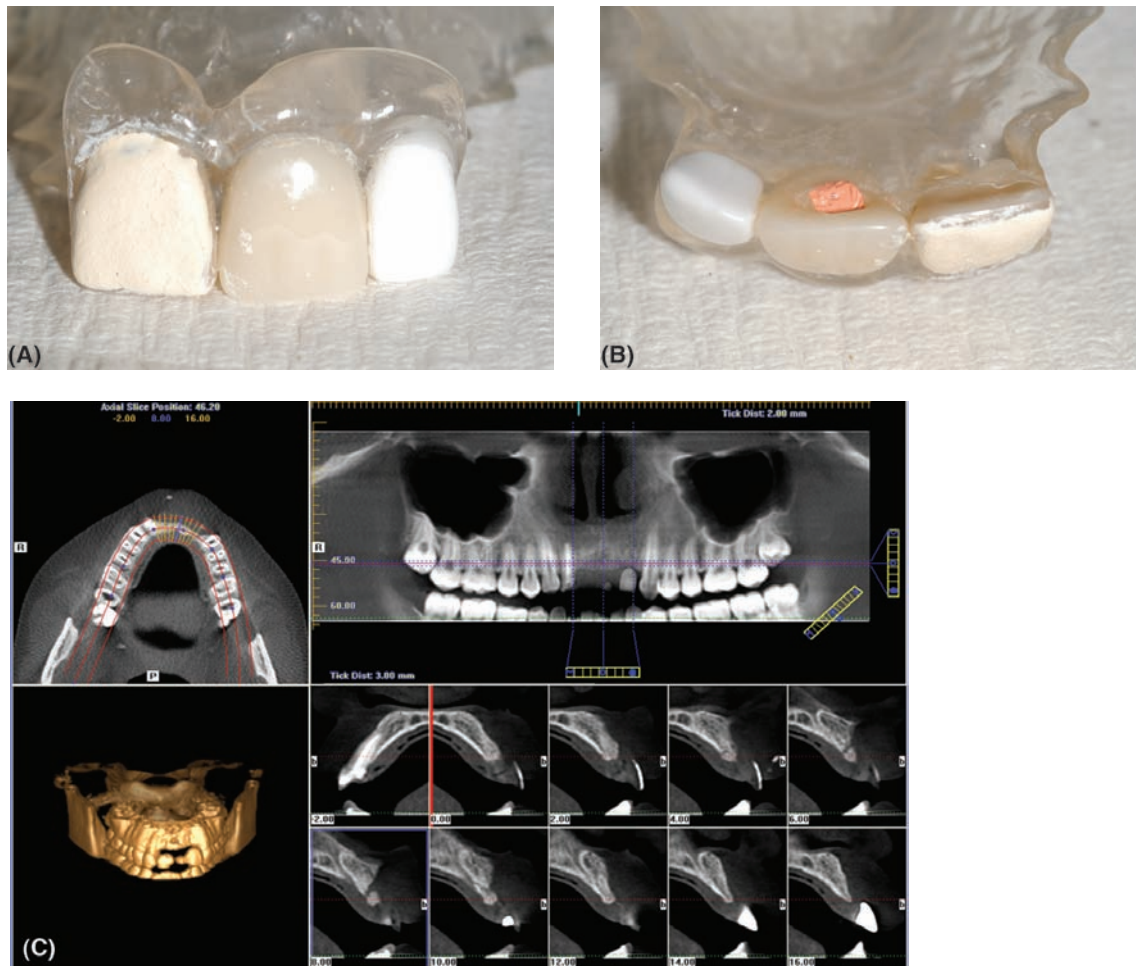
(A) A radiographic stent shown from the labial aspect. The upper right central incisor has a radiopaque medium on the labial surface and the upper left lateral incisor is a manufactured radiopaque tooth. (B) An occlusal view of the radiographic stent showing the upper left central incisor with a gutta percha restoration placed in the cingulum denoting the point of ideal screw access. (C) A cone-beam radiograph of the same case with the radiographic stent in situ showing the relationship of the various radiopaque markers to the underlying ridge form.
